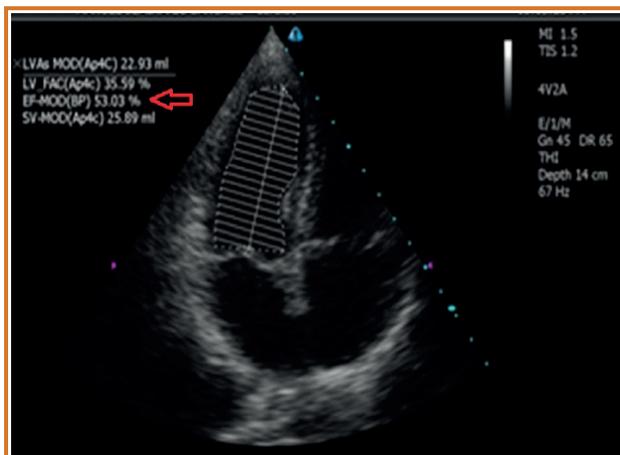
Echocardiographic imaging of the patient with calculation of the left ventricular ejection fraction using the modified Simpson method.
